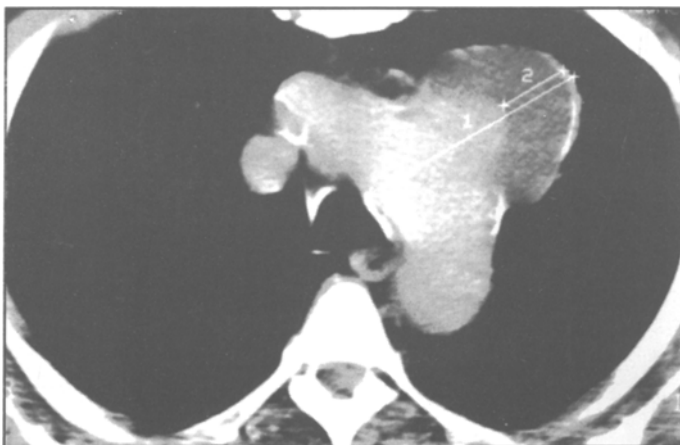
CT Scan showing saccular dilation of arch of aorta 7.56 cm towards left side with peripheral hypodensity of about 2.69 cm and peripheral rim of calcification around thrombus and arch of aorta
